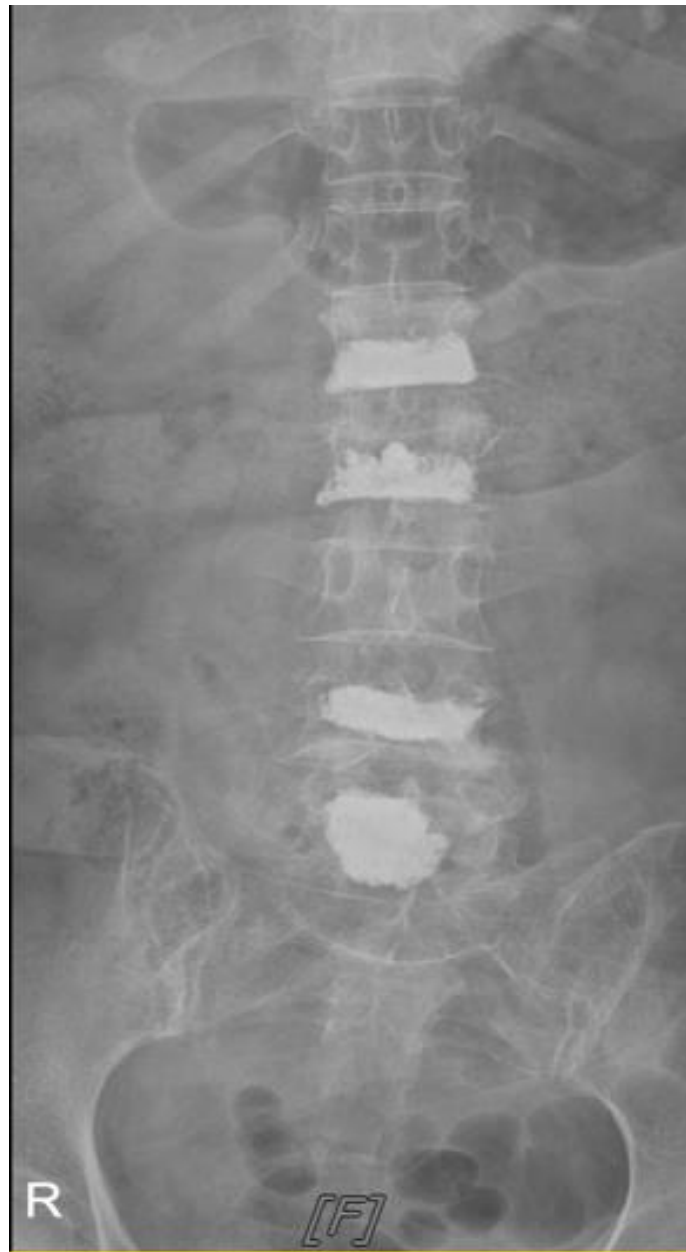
Follow up anteroposterior view of plain radiograph. Post-vertebroplasty state at L1, L2, L4 and L5
